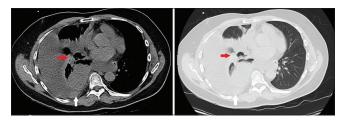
CT chest showing right-sided effusion with pleural-based soft tissue (white arrow) density and a right lower lobe mass (red arrow)
